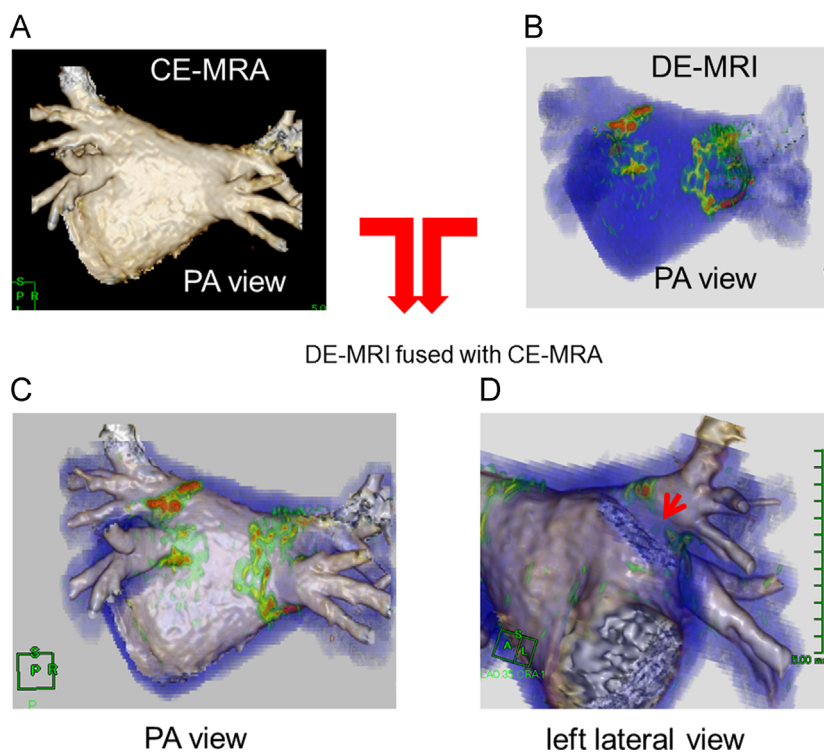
Image quality of the DE-MRI fused with CE-MRA. (A) The 3D reconstructed image using CE-MRA, (B) the 3D reconstructed image using DE-MRI, and (C, D) the 3D reconstructed image using DE-MRI fused with CE-MRA. Of note, the RF lesion gap at the anterior ridge could be recognized (D). CE-MRA=contrast enhanced magnetic resonance angiography; DE-MRI=delayed enhancement magnetic resonance imaging; PA=postero-anterior.
